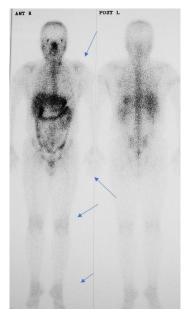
Gallium scintigraphy shows the distribution of mild polyarthritis of the large and small joints in SLE.
